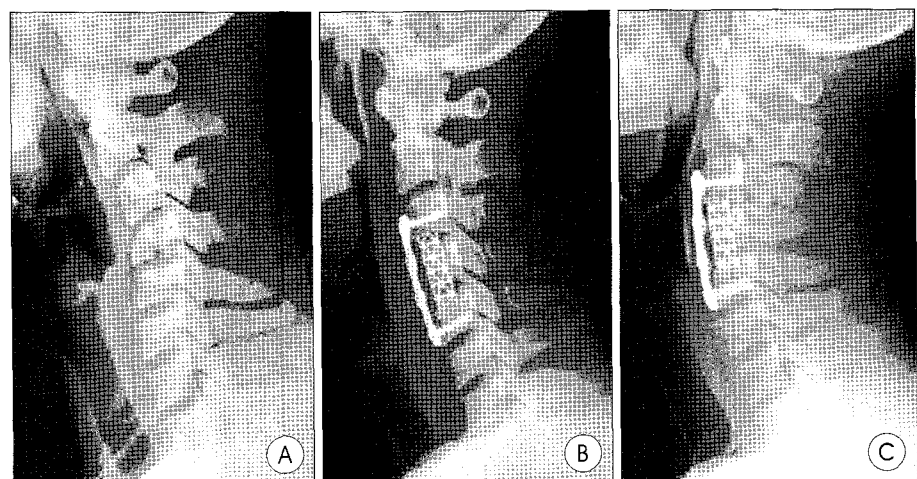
A : Preoperative radiograph of a 37-year-old female with a C4 compression fracture. B : 1-month postoperative radiograph of the same patient after a C4 corpectomy and reconstruction using a 10-mm titanium mesh cage. C : A lateral radiograph 12 months after surgery demonstrating minor pistoning of the cage and extensive bone growth around the cage; but no implant failure and kyphosis. The patient had a cervical lordosis and successful clinical outcome.
